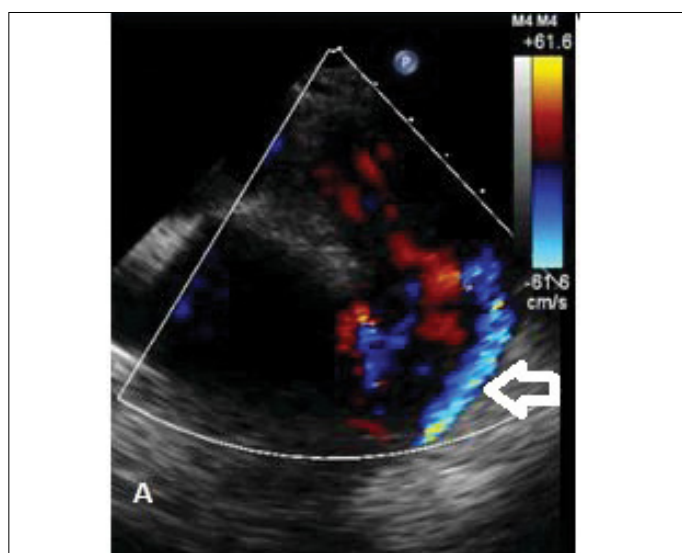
Color Doppler TEE image of a PDA
